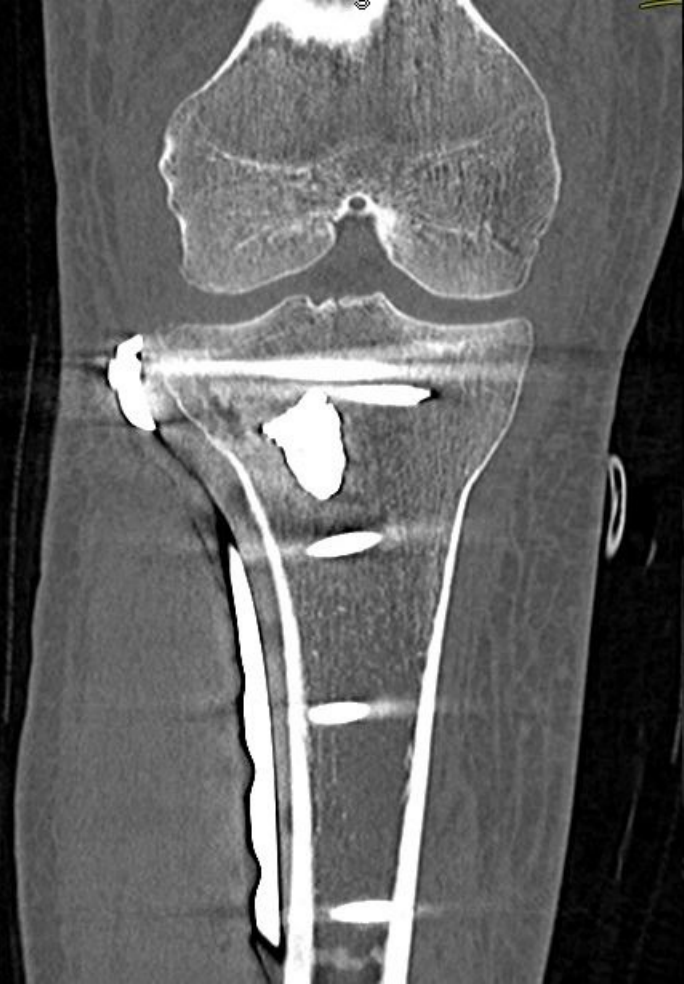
immediate postoperative frontal radiograph
